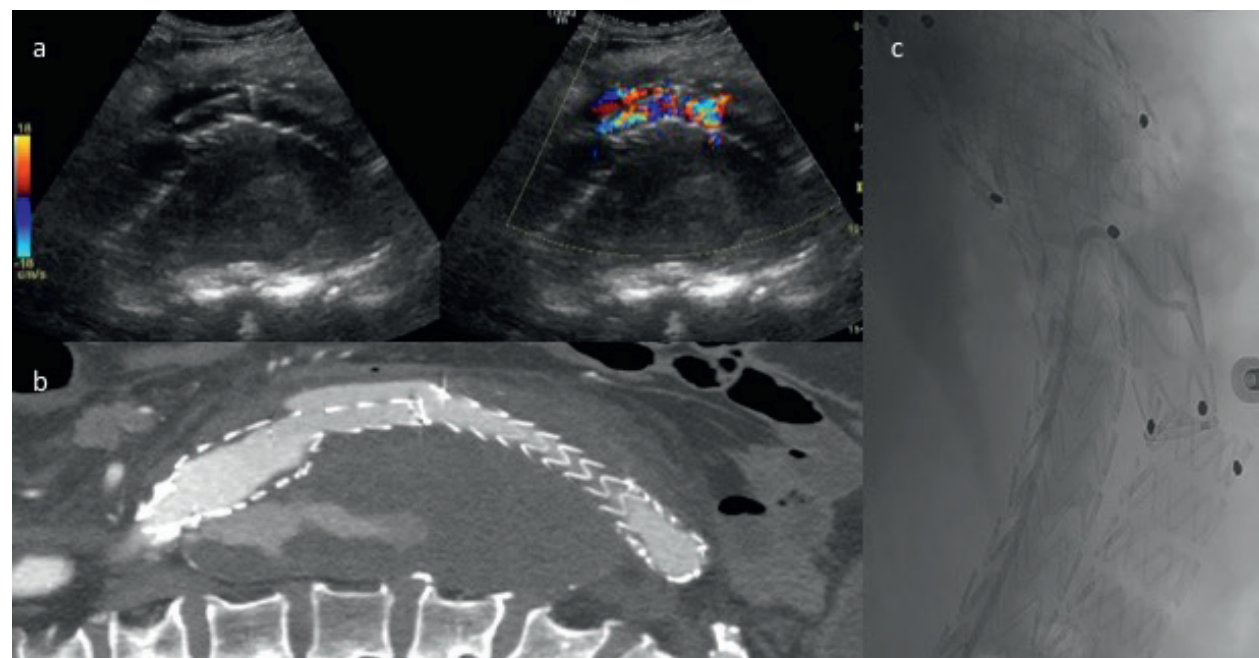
Type III Endoleak. (a) Sagittal greyscale and Doppler sonograms demonstrate flow outside the graft and discontinuity of the graft components. (b) Sagittal contrast enhanced CT (oriented to match US) demonstrate endoleak outside of the graft and confirms ultrasound findings. (c) Aortogram fluoroscopy image shows separation of the components of the endograft.
